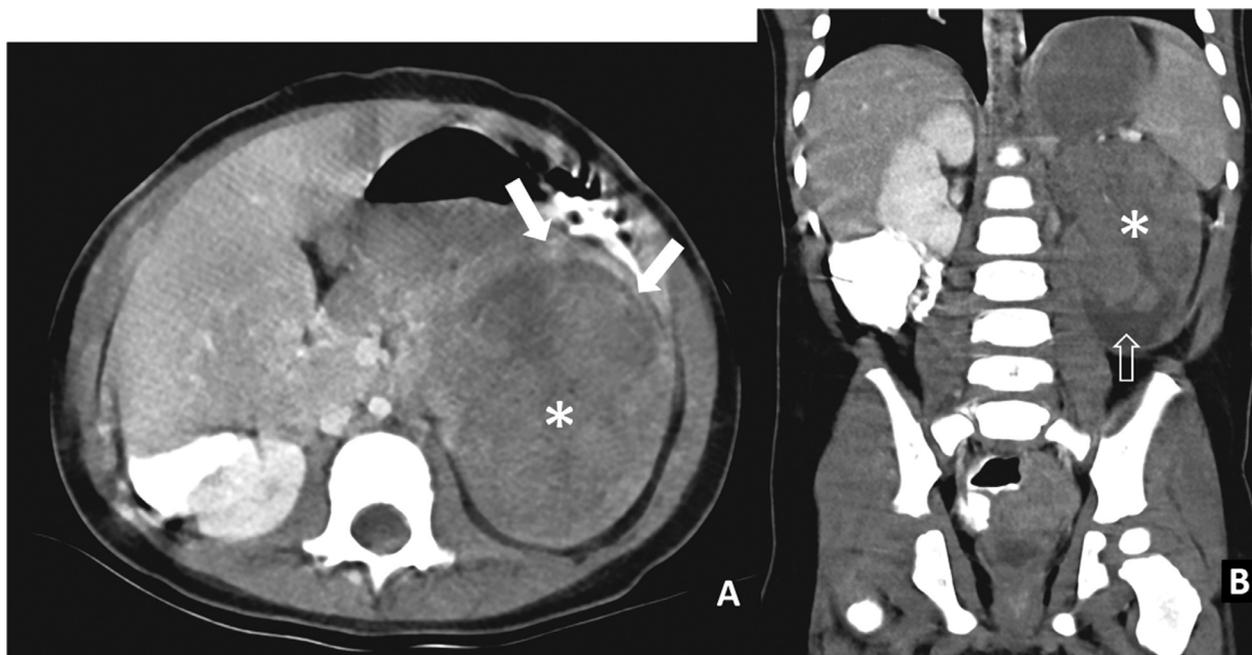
Computed Tomography Images at Diagnosis. (A) Axial images of the abdomen obtained after intravenous contrast administration demonstrate an 8.5 × 5.4 cm left renal mass (asterisk) exhibiting slight hypoattenuation compared to the surrounding renal parenchyma (solid arrows). (B) Coronal images reveal the heterogeneous nature of the tumor with areas of hypoattenuation (open arrow).
